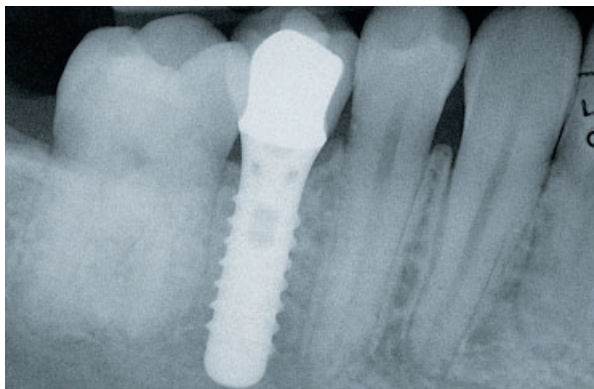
The 5-year radiographic follow-up displays favorable bony conditions around this 12 mm solid screw implant.
